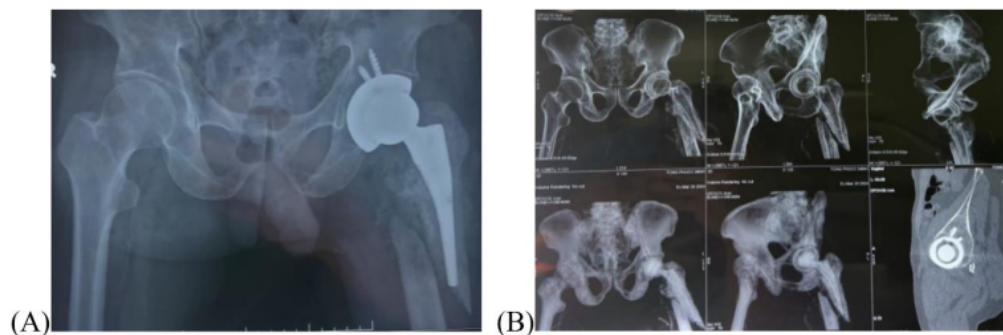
(A) Vancouver B2 Classification; (B) Left hip images on CT Scan
